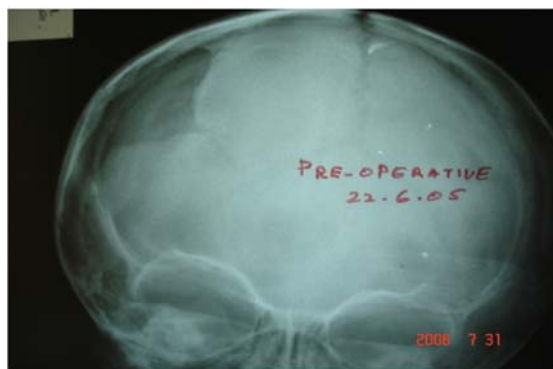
Preoperative AP Skull radiograph showing a well-defined lucency over the right parietal region
